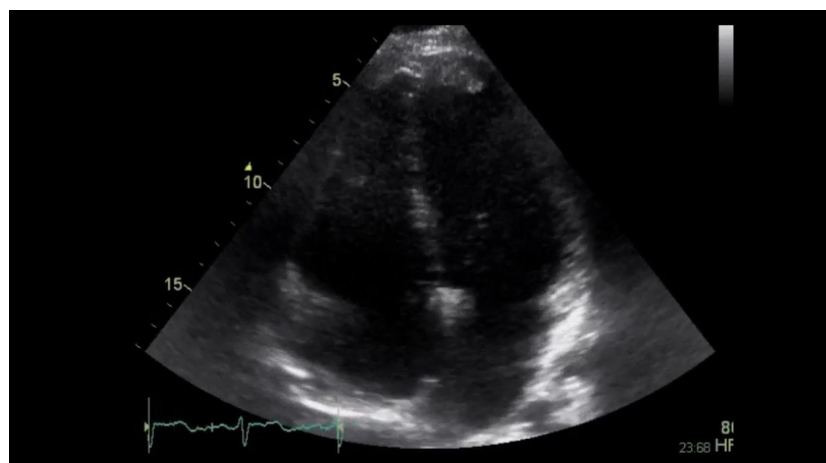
Echocardiogram basal
